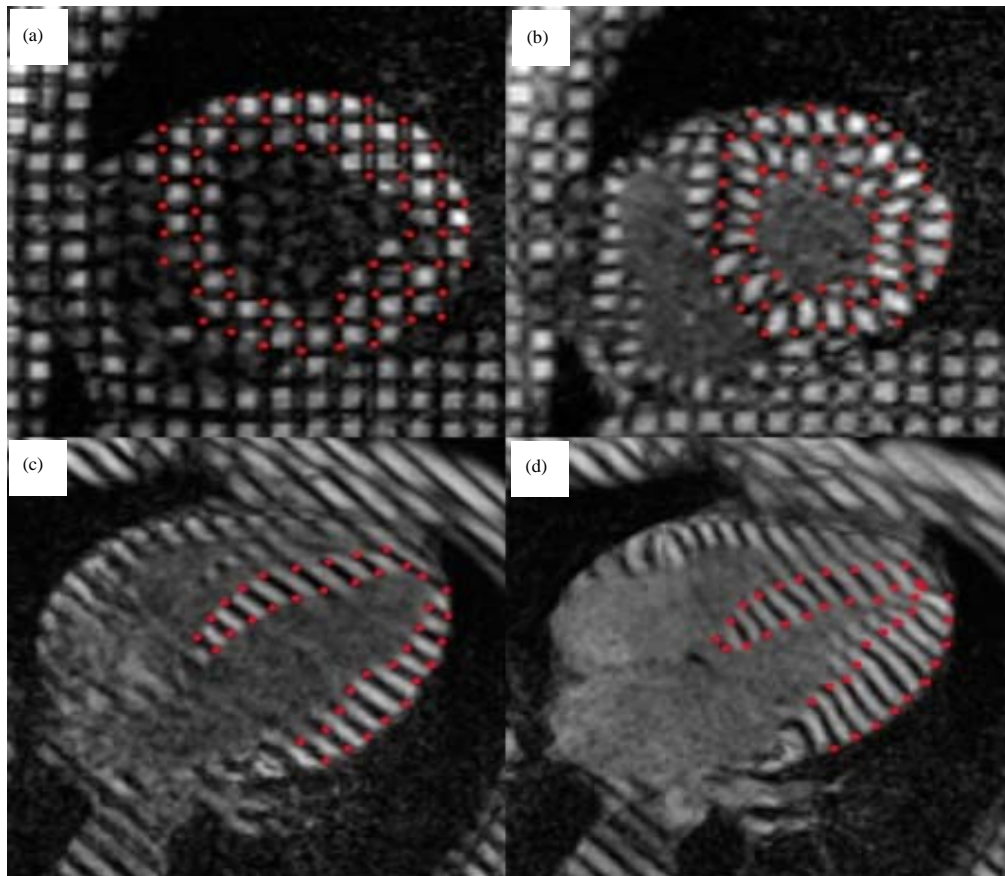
(a-d): MRI study with 2D tagging analysis (a,b) Tagging in cardiac short axis and (c,d) Horizontal long axis, ED (left) and ED time frame (right). Tracking of the grid intersections (indicated in red) on the short axis views and the intersections of the tags with the endo and epicardial border (indicated in red) on the long-axis views, allow analyzing the local myocardial deformation<sup>19</sup>
